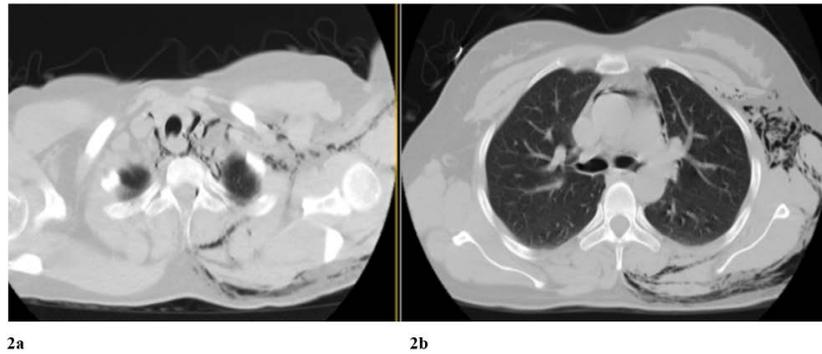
Axial thoracic CT images highlighting the progression and distribution of subcutaneous emphysema and pneumomediastinum. (A): Axial CT of the upper chest on the day of presentation. Extensive subcutaneous emphysema is noted along the thoracic inlet and surrounding the mediastinal structures. Air is visible within the subcutaneous tissues extending from the neck into the thoracic region. (B): Axial CT at the mid-thoracic level showing air pockets distributed within the subcutaneous layers and mediastinum. Clear tracking of gas along the fascial planes is evident, with no compromise of major vascular or airway structures.
